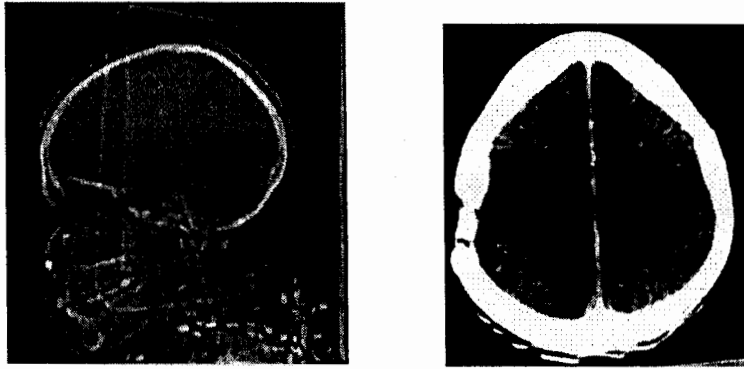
Original Slices of CT of brain
